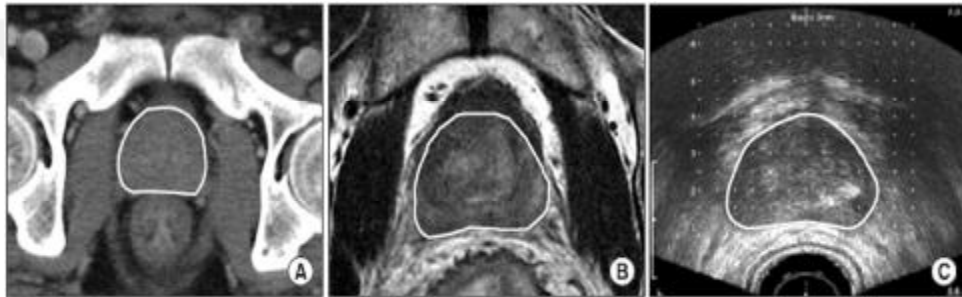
Prostate contours based on different modalities a. CT, b. MRI, and c. TRUS (Park et al., 2011)
